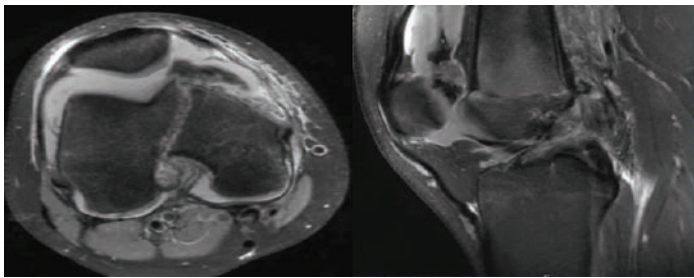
MRI of the right knee demonstrates a minimally displaced fracture of the medial femoral condyle extending into the intercondylar notch as well as a complete tear of the ACL.
